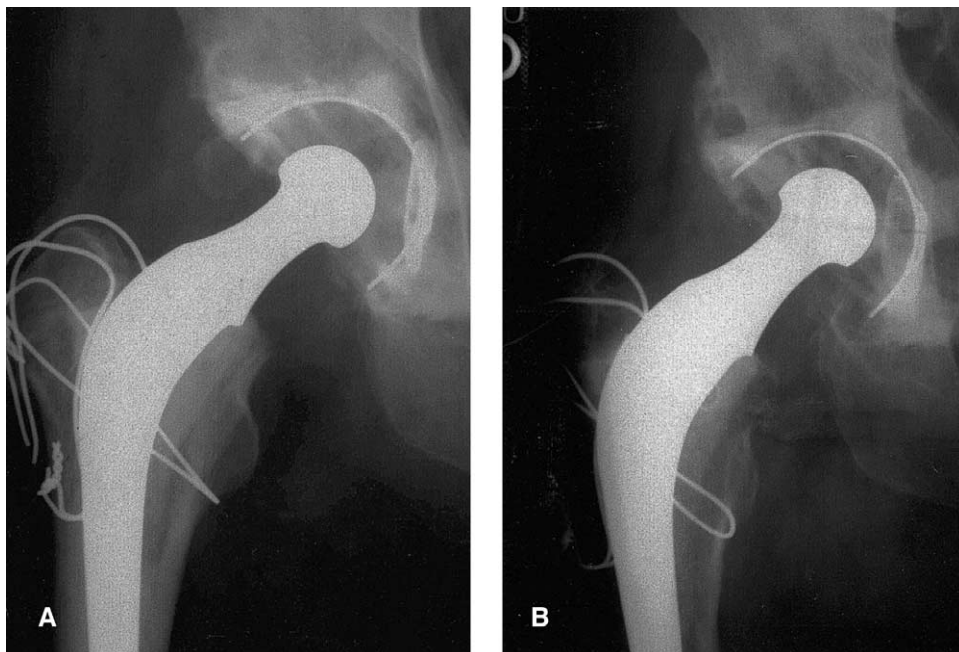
(A) Immediate post-operative and (B) follow-up radiograph taken at 22 years and 7 months postoperatively. The acetabular component is well fixed but does show evidence of polyethylene wear. An osteolytic lesion is present in zone 1.
